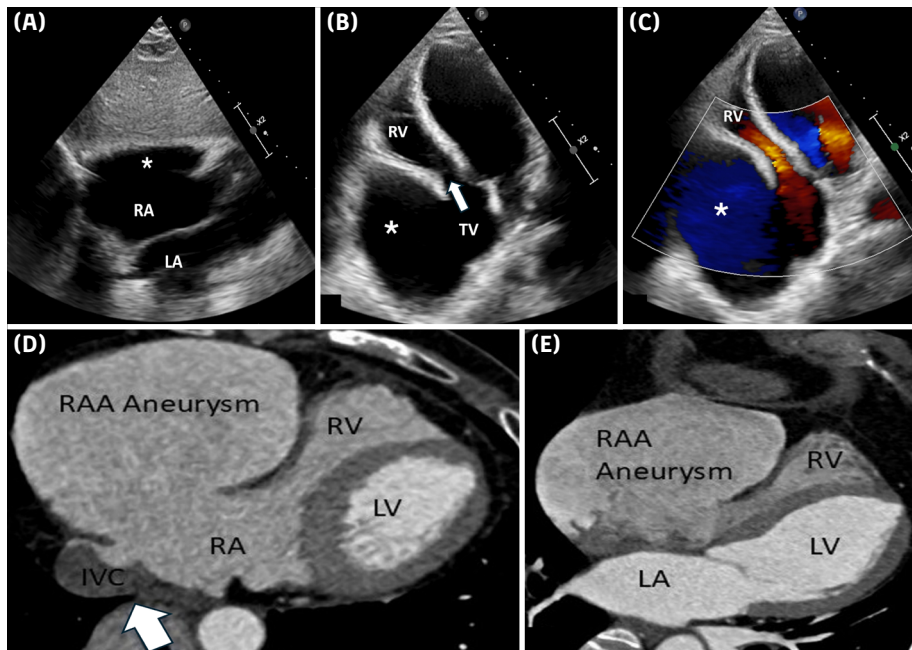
(A-C) Echocardiographic images of the aneurysm of the right atrial appendage (*) in the subcostal long-axis view (A) and apical four-chamber view without (B) and with (C) color Doppler. (D-E) Cardiac tomographic images corresponding to A and B. The aneurysm is seen compressing the right ventricle. The white arrow indicates the tricuspid valve in B and the inferior vena cava in D.
